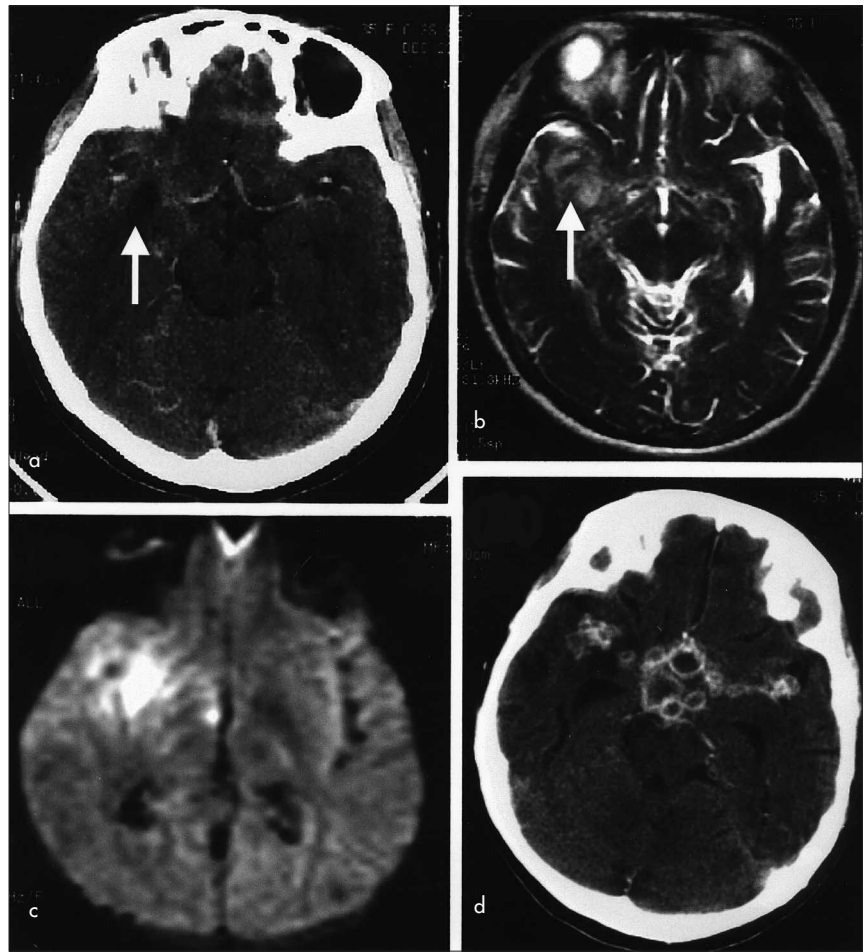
a. Contrast computed tomography brain scan showing a small right temporal lobe infarct (arrow) without contrast enhancement. b. Magnetic resonance imaging showing T2-weighted hyperintense lesion (arrow) over the right anterior temporal lobe. c. Diffusion weighted magnetic resonance imaging showing acute right temporal infarct. d. Contrast computed tomography brain scan showing multiple ring-enhancing tuberculomata.
